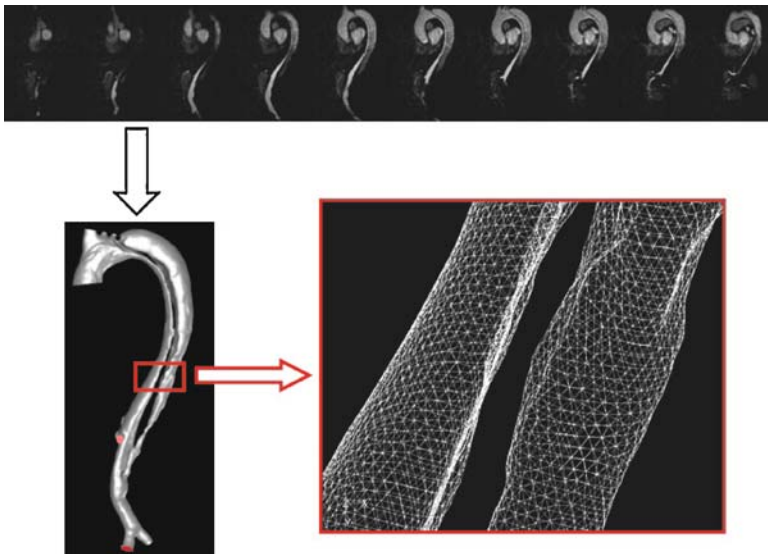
Top*: Selected slices of a 3D ce-MRI acquisition from a patient with TB-AD. *Bottom left*: 3D surface reconstruction depicting well the true and false lumen. *Bottom right*: Detail of computational mesh from red box denoted in image on *left*
